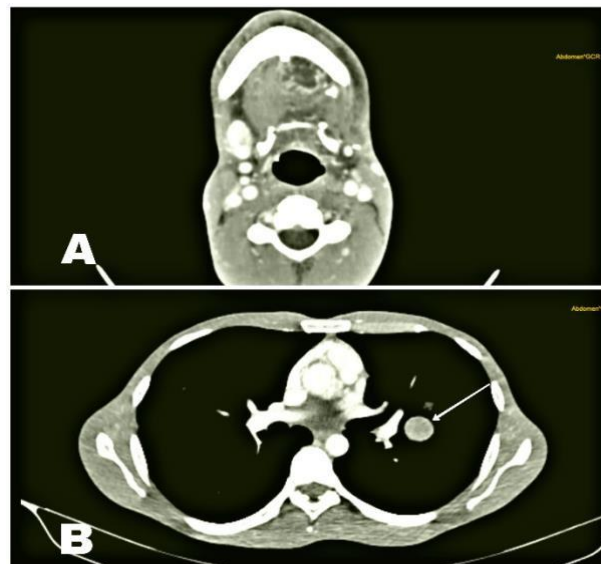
Axial view of contrast-enhanced CT scan images shows A) heterogeneously enhancing residual lesion over left anterior 2/3rd of floor of mouth and tongue. B) lung metastasis in left lower lobe.
